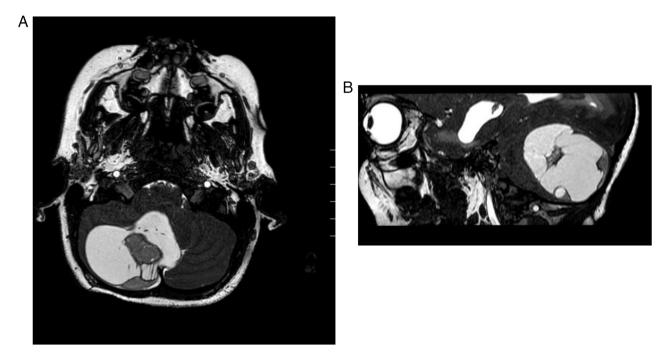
Case of a 6-year-old girl with a long history of headache and morning vomiting, associated with blurred vision and convergent strabismus. (A) Cross-section and (B) sagittal antero-posterior brain MRI showed a voluminous lesion, extensively occupying the vermis and predominantly the right cerebellar hemisphere with a cystic, multi-septal component converging to a solid nodule.
